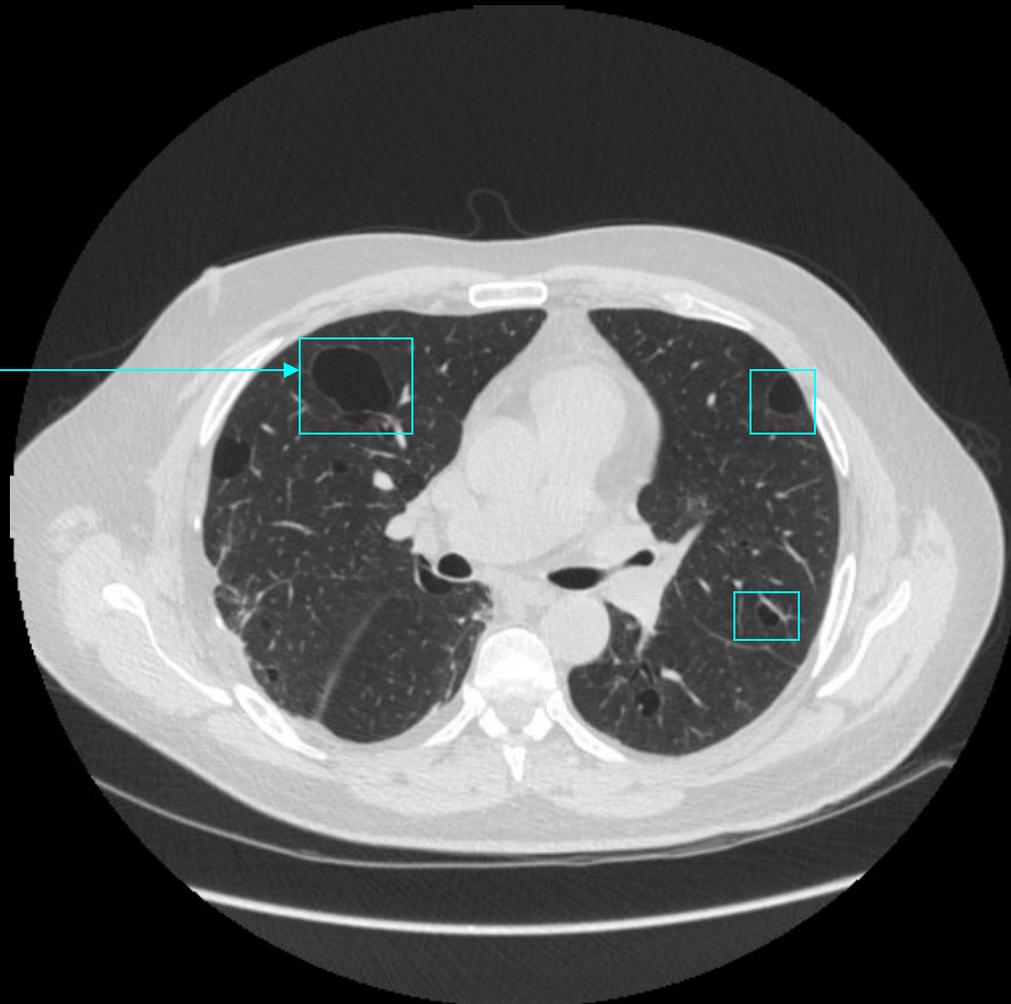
LIP caused by Sjögren syndrome in a 62-year-old woman. Transverse thin-section CT image obtained with patient prone shows diffuse ground-glass opacification and multiple lung cysts (arrows).
